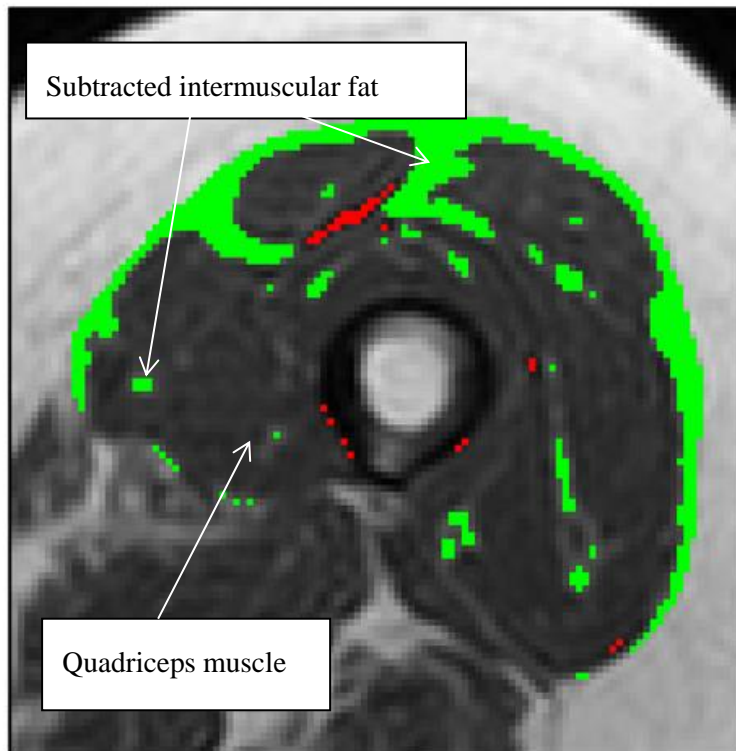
MRI semi-automated k-means fat subtracted quadriceps muscle. Intermuscular fat highlighted in green is identified by the K-means method and subtracted from the manually delineated gross quadriceps area.
